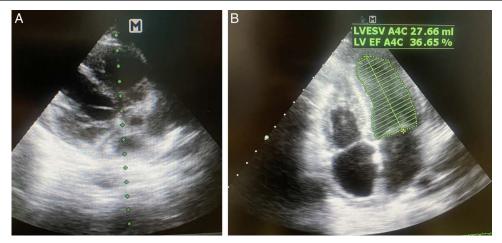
Two-dimensional echocardiograph. (A) Parasternal long axis view showing apical ballooning; (B) four chamber view showing ejection fraction.
